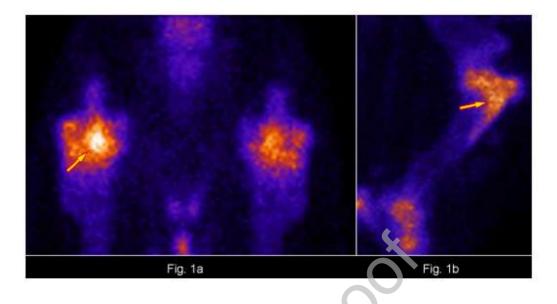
Dorsal (a) and lateral (b) bone-phase scintigraphy of the scapulohumeral region show a focal intense increasing of the radiopharmaceutical uptake (yellow arrow) of the right proximal humerus.
